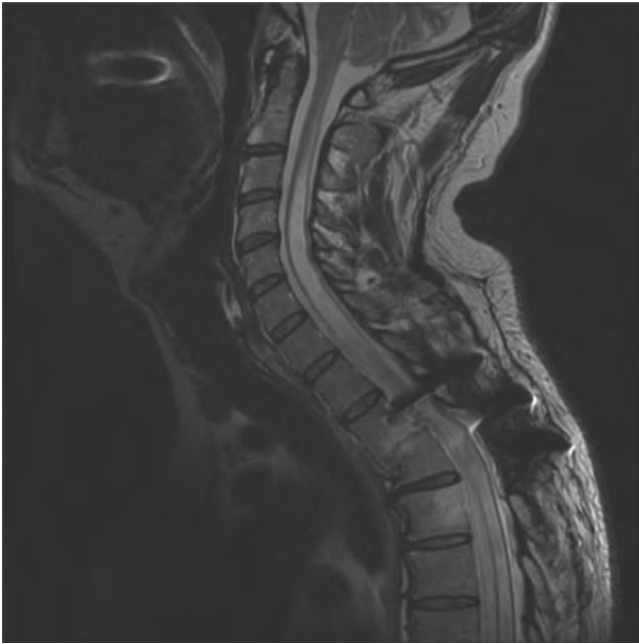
Syringomyelia. Post-traumatic cervico-thoracic syrinx (note T2–3 trauma and artefact resulting from pedicle screws) (MRI T2W).
